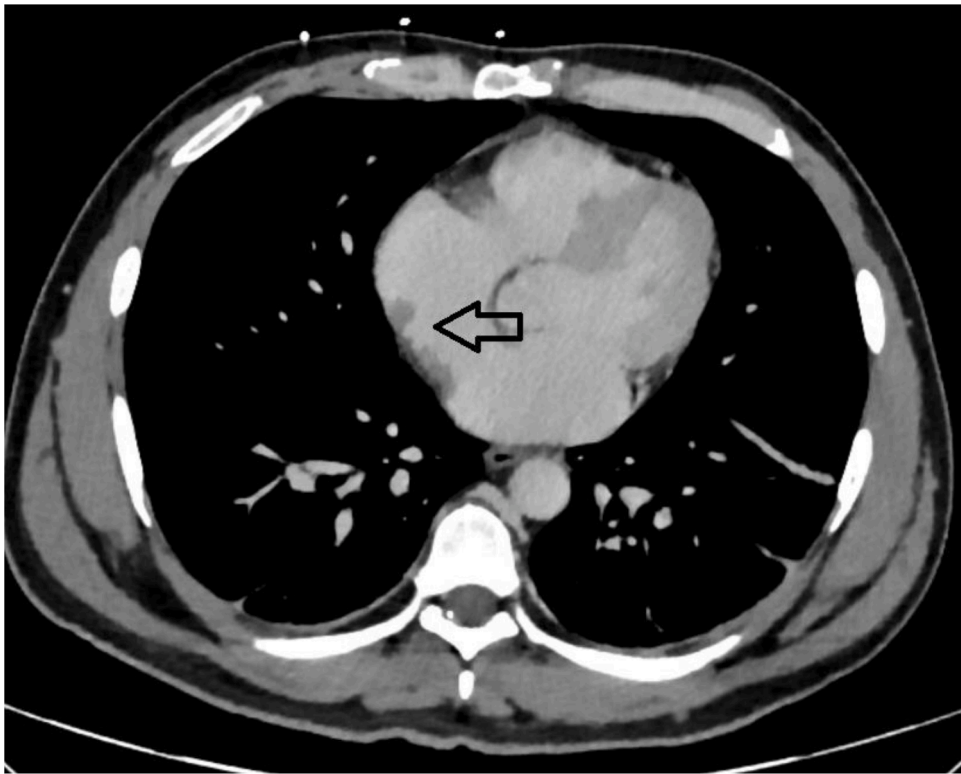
CT thorax shows 10 mm nodule along the lateral wall of the right atrium in the region of the crista terminalis (black arrow).
